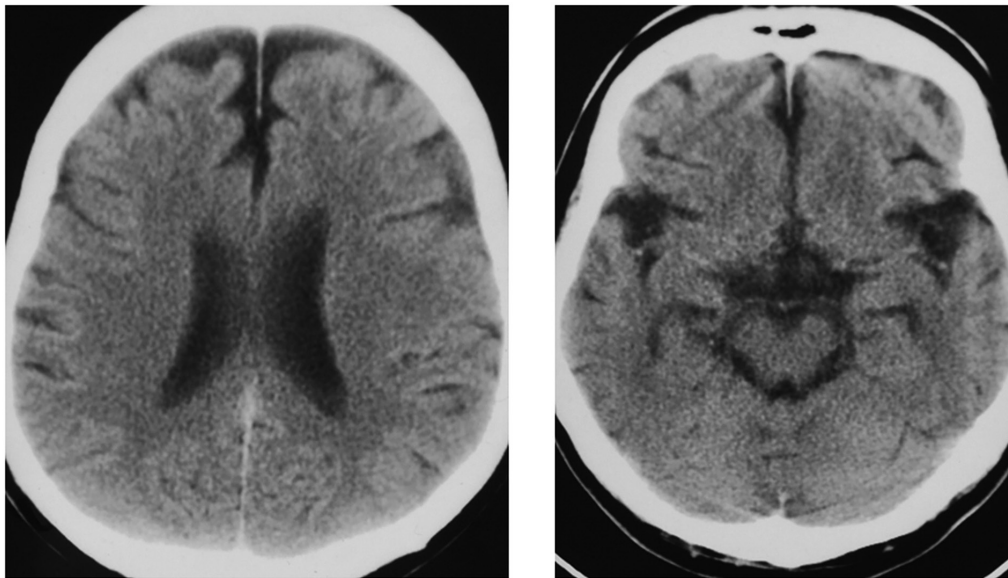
Brain computed tomography images of the patient at 49 years of age (July 2002). No atrophy of the frontal lobe or midbrain tectum can be observed.
